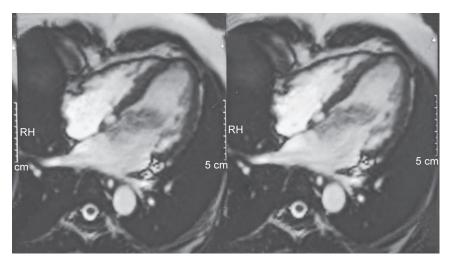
Cardiac T2w MRI showing left atrial myxoma
